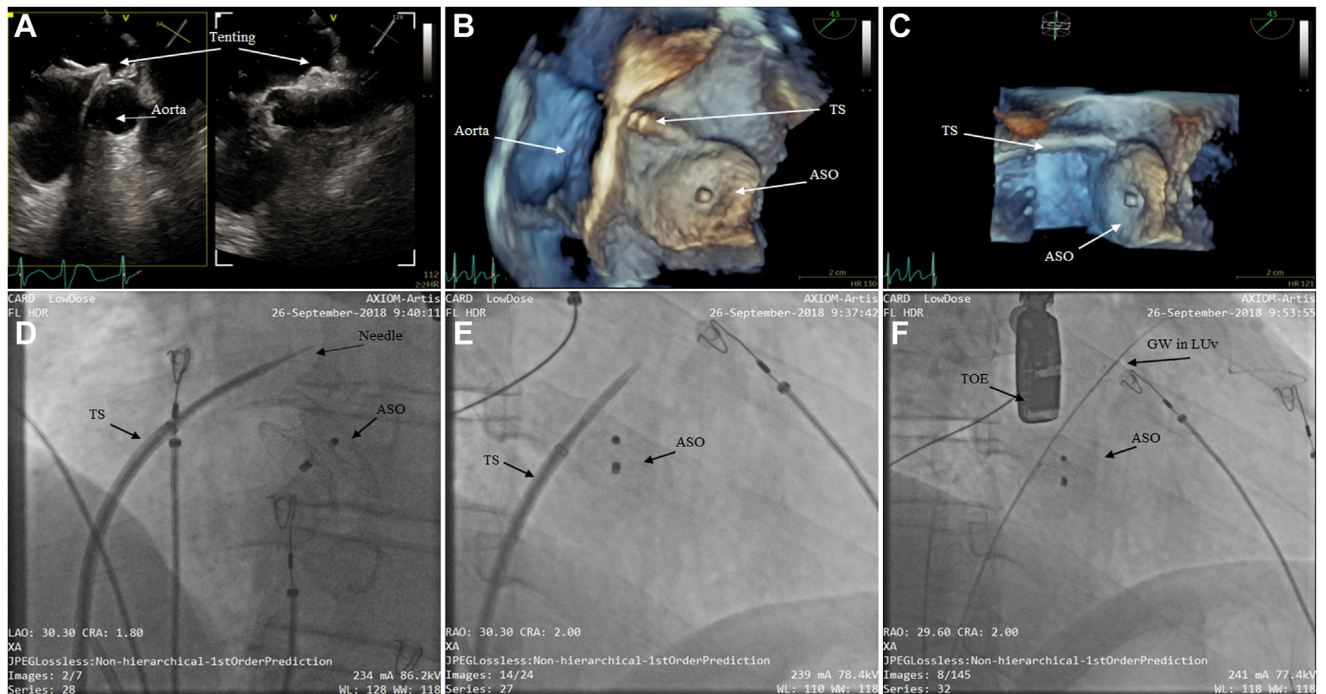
Anterosuperior transseptal puncture compared to the atrial septal occluder (ASO) device in native septum. A: Two-dimensional X-plane transesophageal echocardiography (TEE) image showing needle tenting on the native septum. B, C: Three-dimensional TEE reconstructions showing the puncture anterosuperior in the native atrial septum above the device occluder (ASO) and the 12F transseptal sheath (TS). D: Fluoroscopy, left anterior oblique showing the 8.5F TS and needle. E: Right anterior oblique (RAO) view. F: RAO view; after puncture the guidewire (GW) was advanced in the left upper (LU) pulmonary vein.
